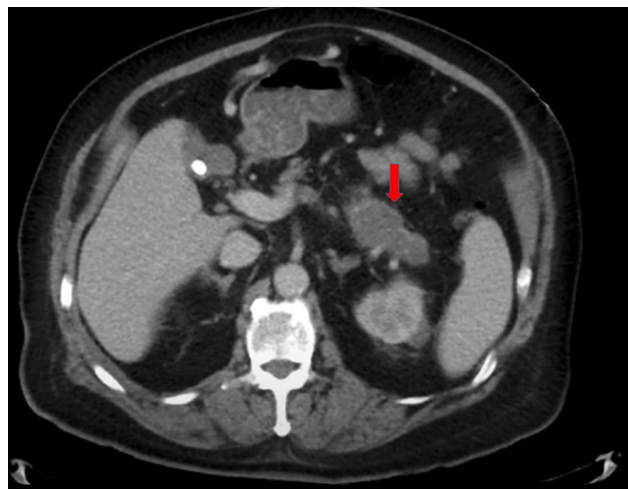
Thoraco-abdomino-pelvic CT scan showing a pancreatic tail tumor.
